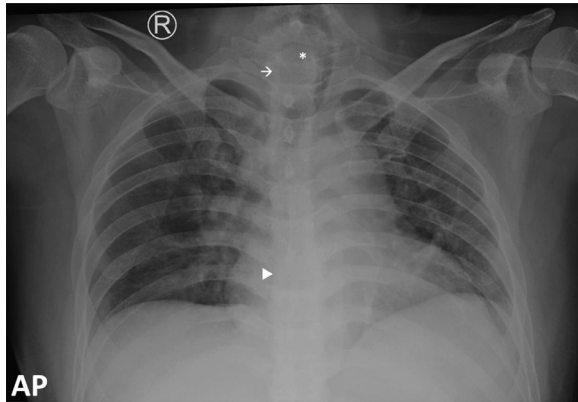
Chest X-ray showed soft tissue mass at C6-T1 level (asterisk) that pushed the trachea to the left, blurring of the T1 pedicle (arrow) and deformity of the T7 vertebral body (arrowhead); with no lung metastasis.
